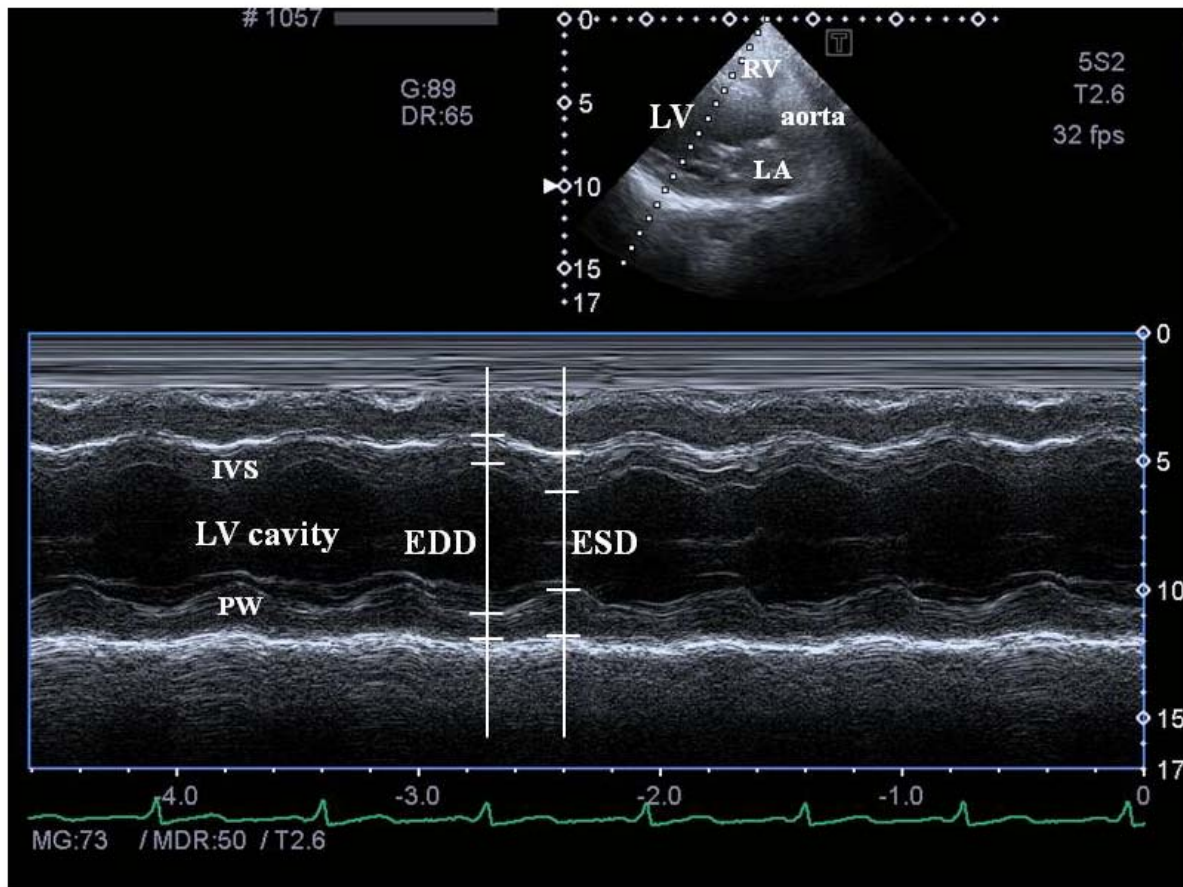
Assessment of left ventricular dimensions in parasternal long-axis view by two-dimensional echocardiography using Techholz-methodology.
